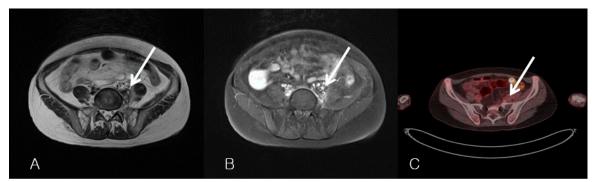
Representing abdominal lymph node metastasis ant its invasion to psoas muscle 1A. MRI T2 image, 1B. MRI T1 image, 1C. PET scan image
